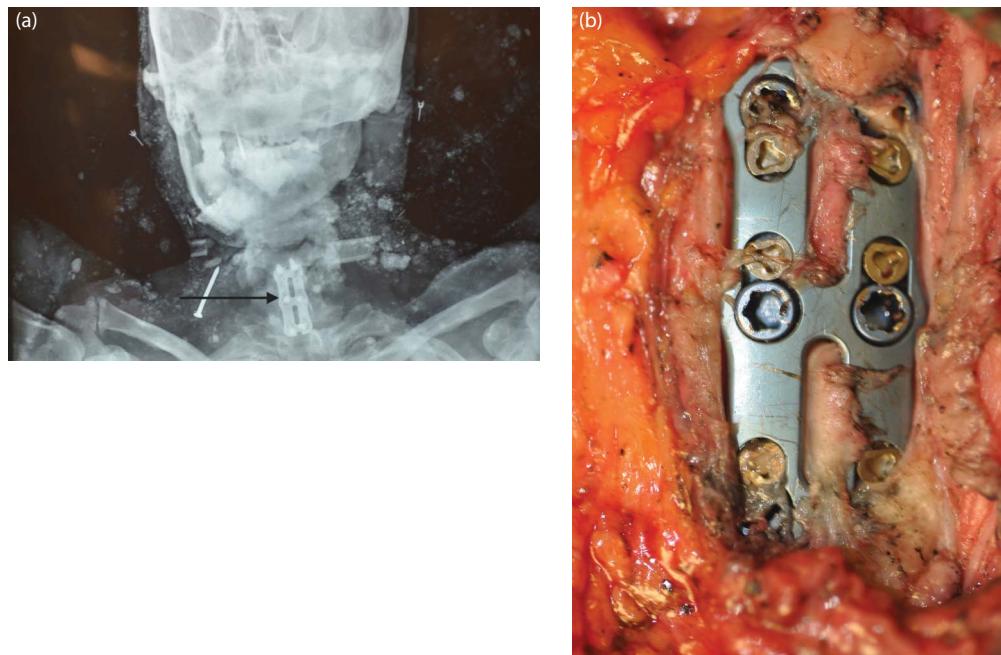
(a and b) Identification by neck plate and screws. Postmortem films of the neck show a plate and screws. Inquiry reveals the purported victim had neck fusion surgery. Medical records can be checked for old radiographs (x-rays), plate and screw brands, and serial numbers.
